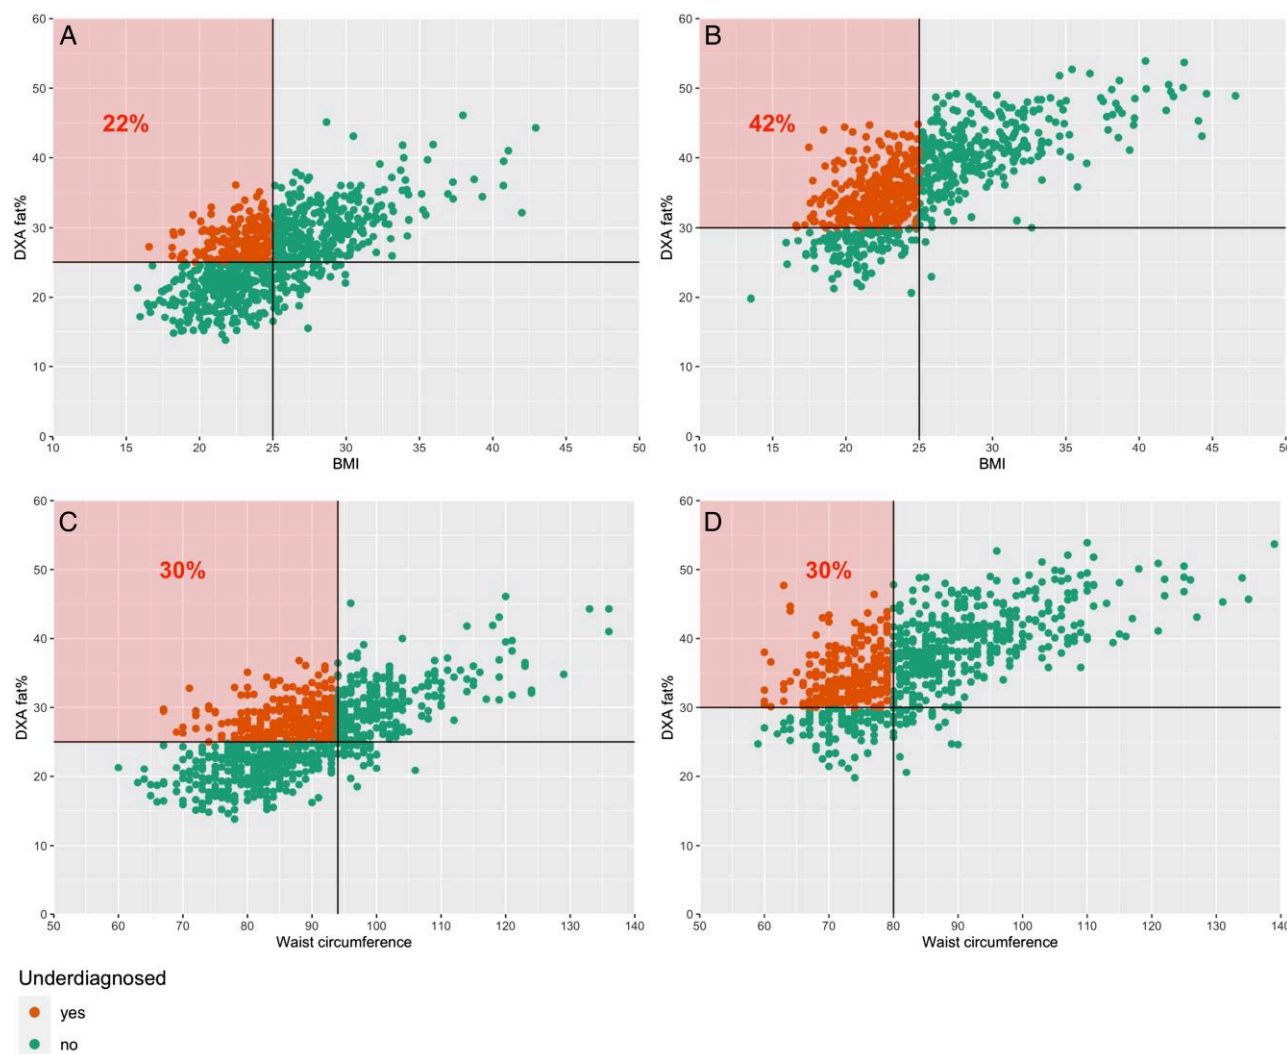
Comparison of overweight classification using BMI and waist circumference vs DXA scan. Underdiagnosis of overweight, when compared to fat percentage on DXA scan, with BMI in men (panel A) and in women (panel B), and with waist circumference in men (panel C) and in women (panel D). The upper-left square and percentage in each figure indicate the survivors with high fat percentage and normal waist circumference or BMI. DXA, dual-energy X-ray absorptiometry; BMI, body mass index.
